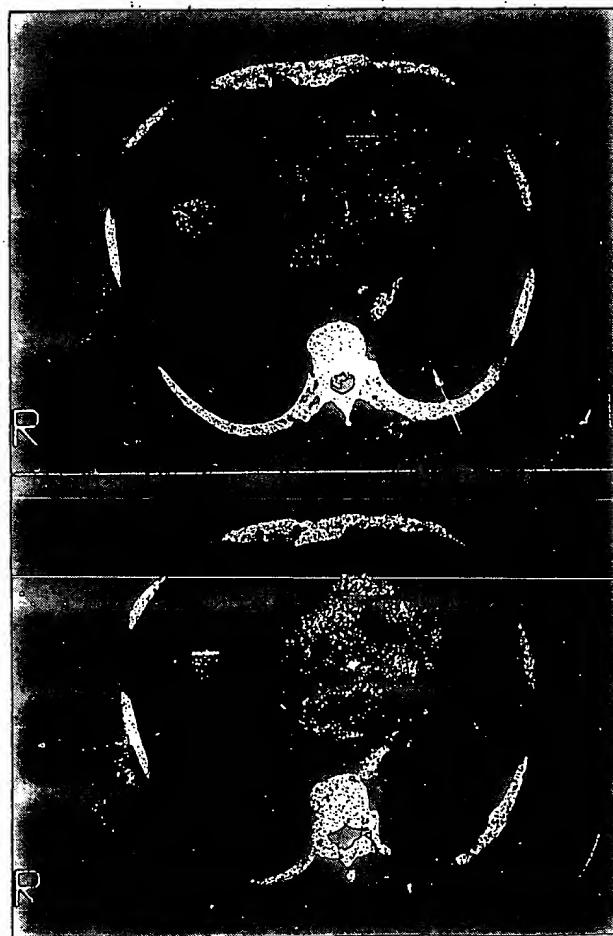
Top, A computed tomogram at the start of treatment in patient 29 shows a large pulmonary nodule (arrow) in the left posterior lung. Bottom, A computed tomogram taken 60 days later shows regression of the nodule in the left posterior lung.
